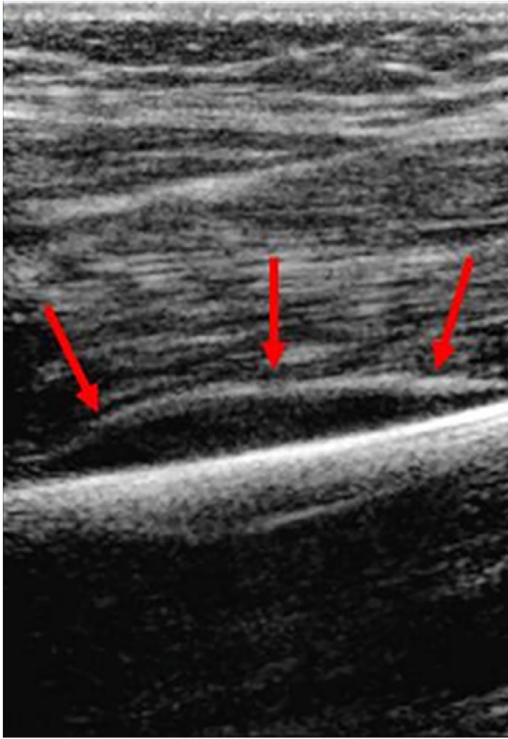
Thickening of the periosteum with hypoechoic zones both superficial and deep to the periosteal layer, referred to as the 'periosteal sandwich' sign (red arrows). (Image courtesy of Inusa et al (Inusa BP, Oyewo A, Brokke F, Santhikumar G, Jogeessvaran KH. Dilemma in differentiating between acute osteomyelitis and bone infarction in children with sickle cell disease: the role of ultrasound. *PLoS One*. 2013 Jun 6;8(6):e65001. <https://doi.org/10.1371/journal.pone.0065001>. PMID: 23755165; PMCID: PMC3675051.)
